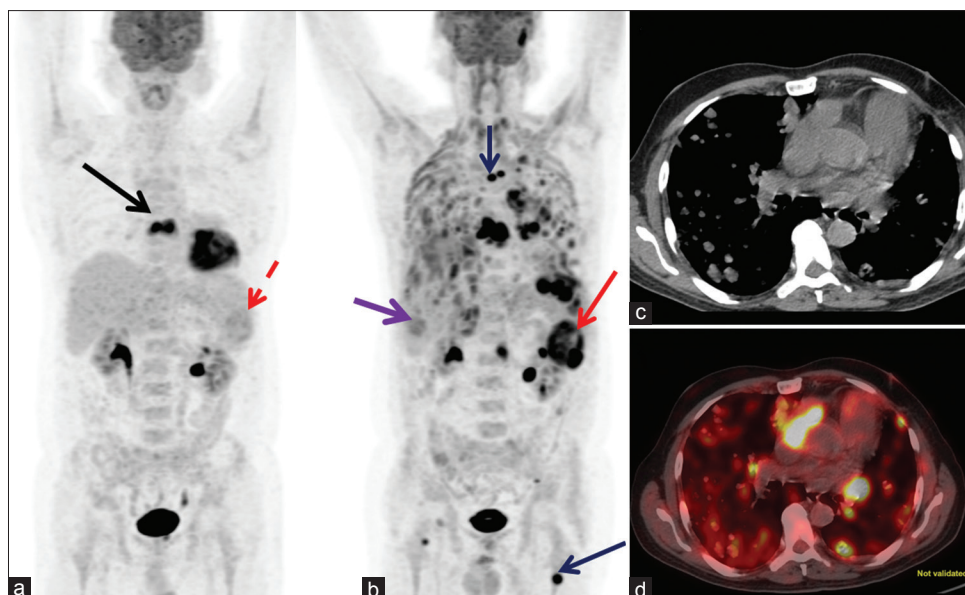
(a) Pretherapy ¹⁸F fluorodeoxyglucose positron-emission tomography-computed tomography maximum intensity projection image showing focal increased fluorodeoxyglucose uptake in the thorax region (solid black arrow) suggestive of cardiac angiosarcoma. Dashed-red arrows show increased fluorodeoxyglucose uptake in the liver, spleen, thorax, and pelvis suggestive of metastases. (b) Posttherapy ¹⁸F fluorodeoxyglucose positron-emission tomography-computed tomography maximum intensity projection image showing increased fluorodeoxyglucose uptake in the liver, spleen, thorax, and pelvis suggestive of metastases. (c) Trans-axial computed tomography image showing soft-tissue lesion in the right atrial appendage (d) Fused trans-axial positron-emission tomography-computed tomography image showing increased fluorodeoxyglucose uptake in the right atrial appendage suggestive of cardiac angiosarcoma
